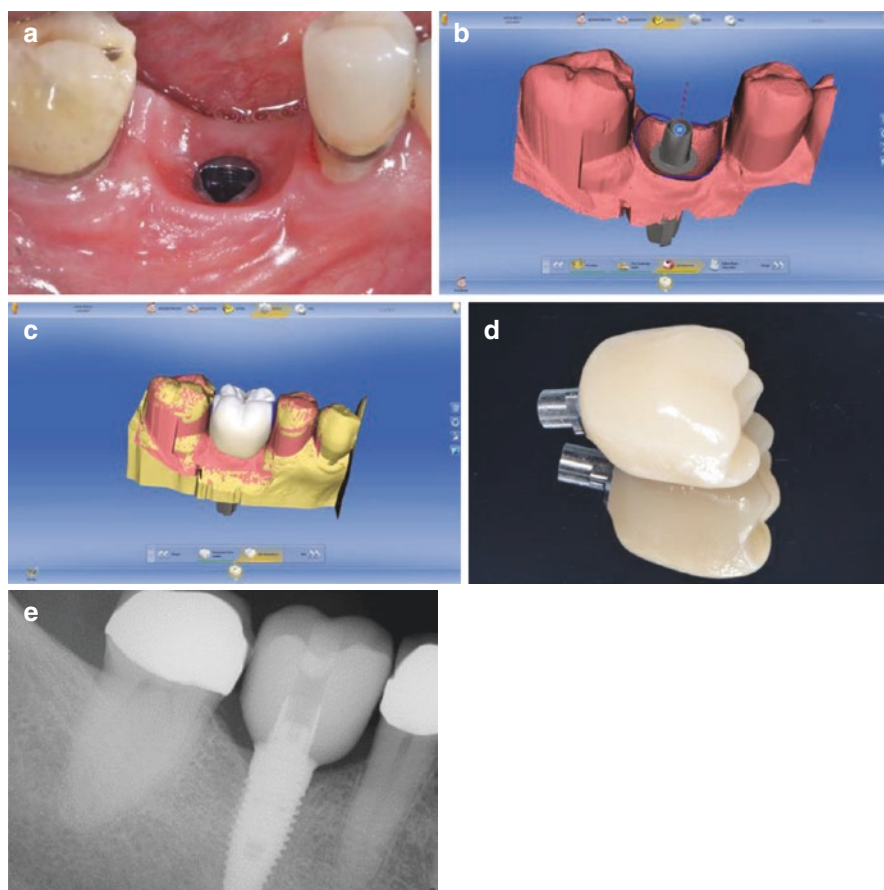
(a) Nobel Biocare Replace Select 5.0 in the position of #30. (b) Determining the emergence profile with the chairside CEREC software v 4.4.4. (c) Designing the screw-retained crown with the chairside CEREC software. (d) Enamic hybrid abutment crown (screw retained). (e) Radiograph of final restoration in place
